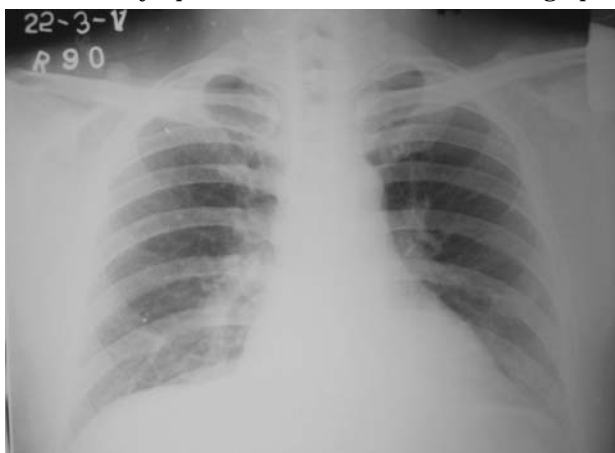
Chest radiograph (postero-anterior view) reported to be normal. This was obtained 3.4 years after the diagnosis of sarcoidosis when the patient was diagnosed to have smear positive TB lymphadenitis.
